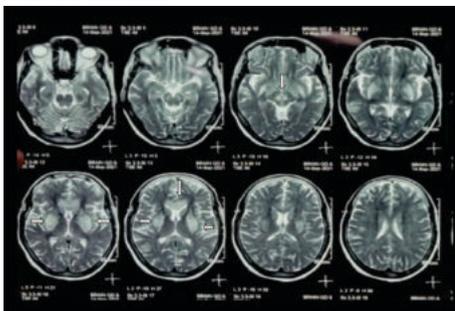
AXIAL T2W MRI Shows Symmetric Hyperintensities In Bilateral Subthal Amus, Midbrain, And Pons
